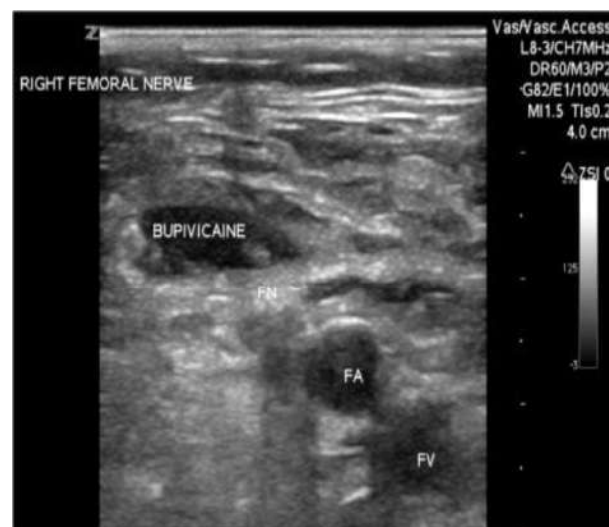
Ultrasound image of femoral vein, artery (FA), nerve (FN) and inguinal ligament (IL) and expanding bupivacaine around FN
